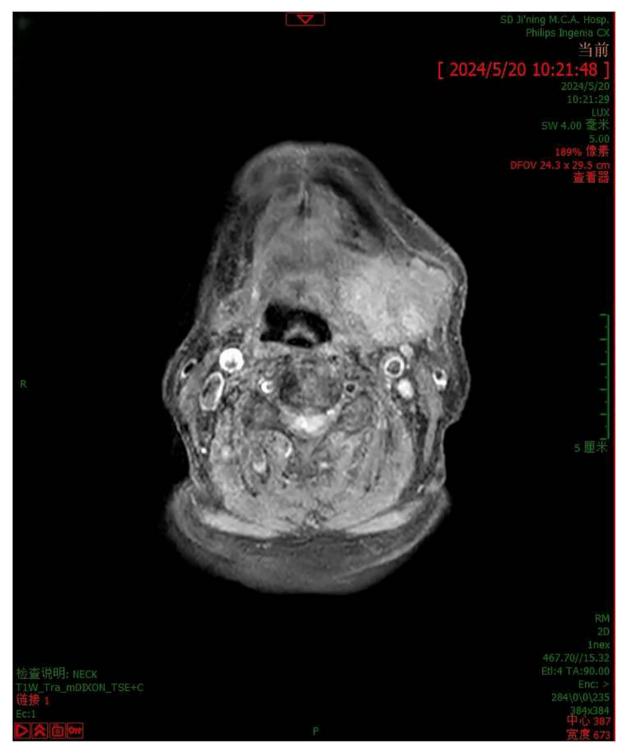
MRI shows a tumour in the region of the left submandibular gland.
